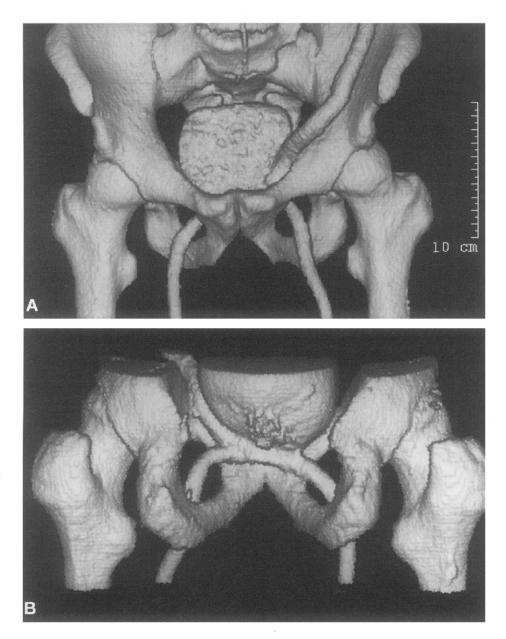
Helical computed tomogram of pelvic region reconstructed to show prosthetic graft. A, Anterior view demonstrates graft descending in left iliac fossa to join transobturator graft, which is seen exiting through both obturator foramina. B, Posterior view with removal of sacrum shows aortic graft anastomosed to transverse segment of transobturator graft behind urinary bladder.
